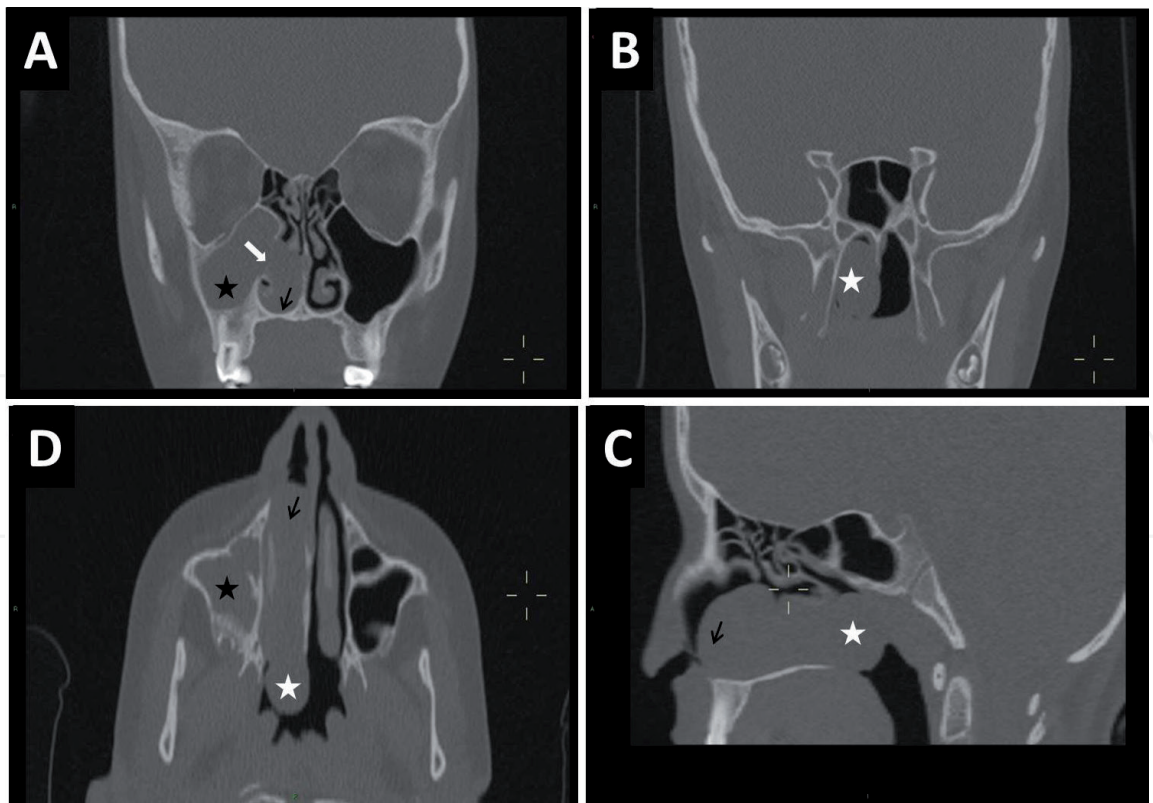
Computed tomography (CT) imaging of right-sided antrochoanal polyp (ACP). (A) coronal image showing total opacification of the right maxillary sinus and nasal cavity. The antrochoanal polyp has both an intramaxillary component (black asterisk) and an intranasal component (black arrow) this view also demonstrates the enlarged accessory maxillary ostium (white arrow) through which the intramaxillary and intranasal portions are connected via a thin stalk. (B) Coronal view of choanal component of the polyp (white asterisk) obstructing the nasopharynx on the ipsilateral side. (C) and (D) axial and sagittal views demonstrating the different components of the antrochoanal polyp intra-maxillary (black asterisk), intranasal (black arrow) and choanal / nasopharyngeal (white asterisk) portions.
